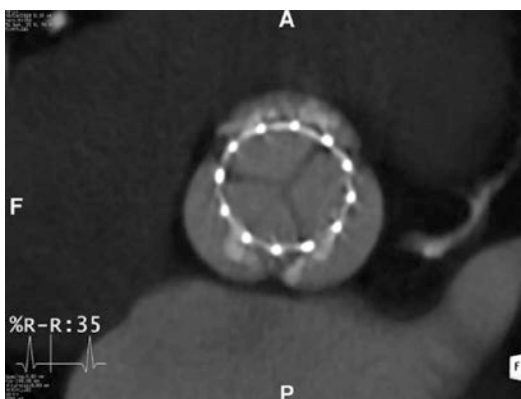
Normal appearing bioprosthetic valve on cardiac CT
